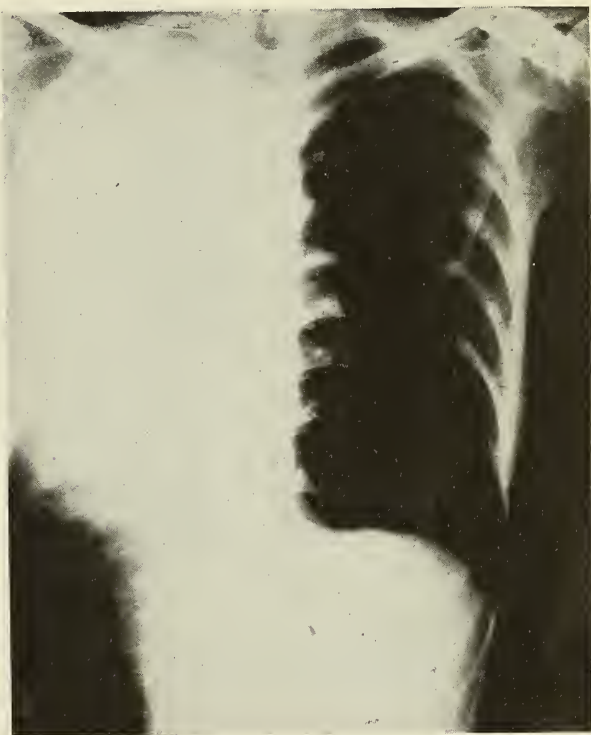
Collapse of larger part of left lung. Note compensatory emphysema on right with depression of diaphragm. The left portion of the diaphragm is high, the trachea only moderately deflected to the left and the right border of the heart not discerned to right of sternum. Roentgenogram taken first day of atelectasis.
